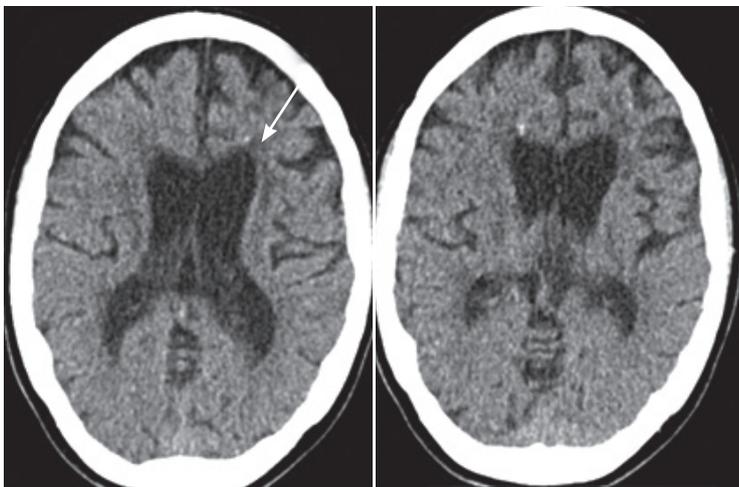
Cerebral CT at the first visit. Generalized supratentorial atrophy inconsistent with an age of 32 years and multiple spotty calcifications in the frontal white matter (arrow).
